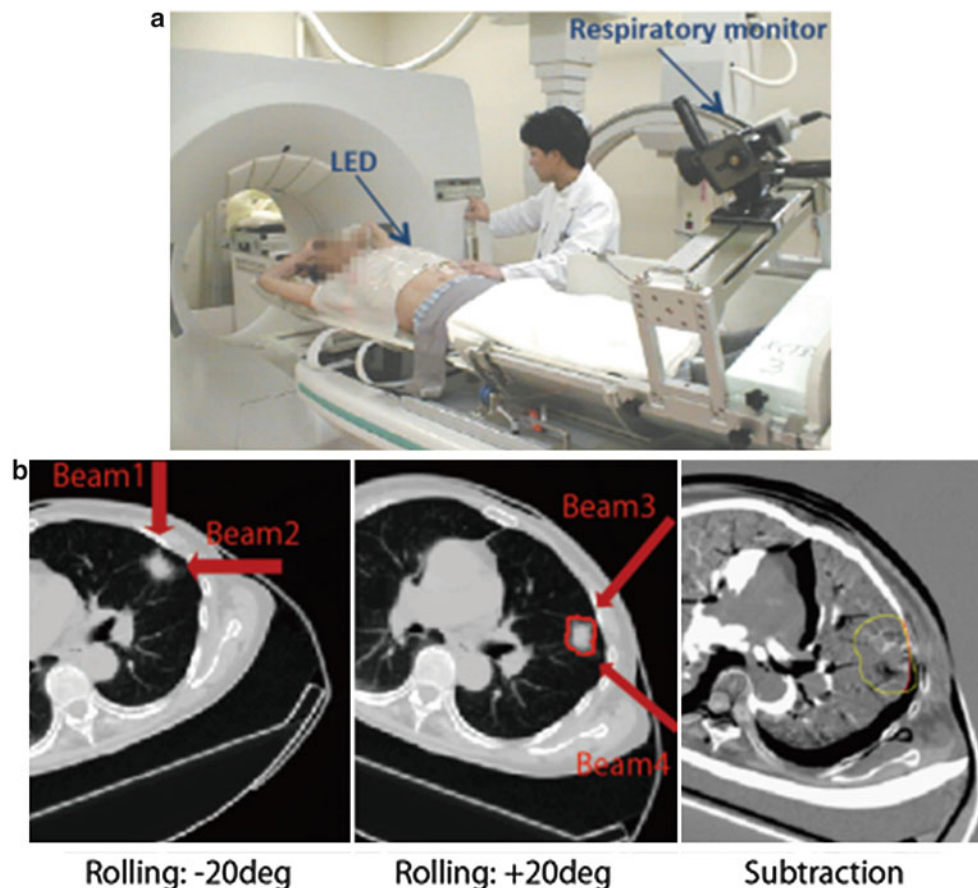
(a) Respiratory correlated CT scan. (b) Left and middle panels: Axial CT images with the rotation of $+20^\circ/-20^\circ$. Right panel: Subtracted image using left and middle panels by registered by tumor position
